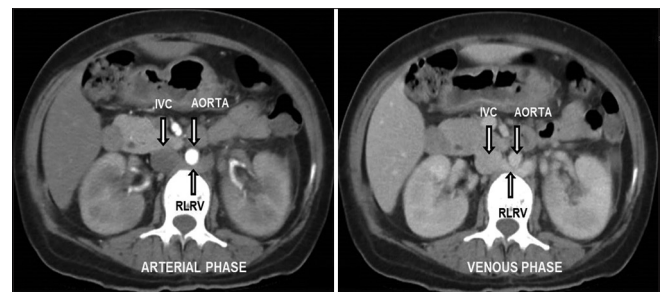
Computed tomography scan of the abdomen showing the course of RLRV
